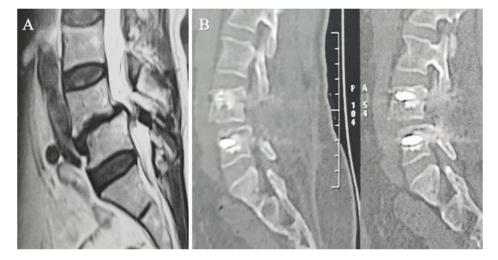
A 52-year-old female patient with isthmic L4-L5 spondylolisthesis: (A) preoperative sagittal T2 MRI showing L4-L5 spondylolisthesis with subsequent canal stenosis; (B) 12-month postoperative sagittal CT cuts showing shadows of bone cement within the vertebral bodies around the screws.
